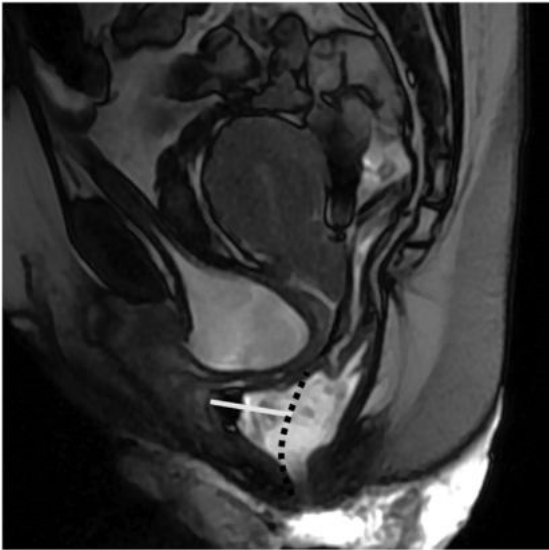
Rectocele. Sagittal MRI T2WI shows anterior rectocele. Anteroposterior diameter (grey line) is measured from the most anterior aspect of the rectal protrusion to the expected margin of the normal rectal wall (dashed black line).
